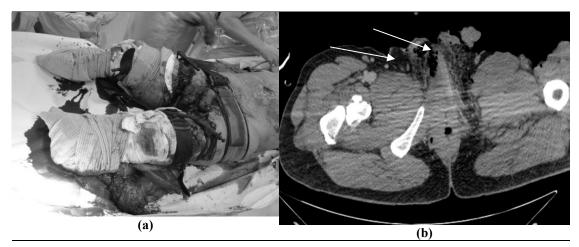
(a) Bilateral traumatic above knee amputation and pelvic injury (binder placed) (b) axial CT scan of significant perineal soft tissue injuries.
